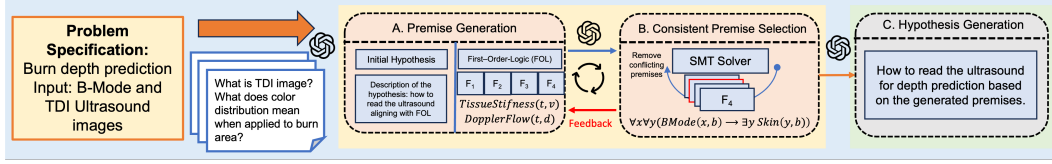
Automated hypothesis generation pipeline. Given the problem specification (burn depth prediction using B-Mode and TDI ultrasound), the system first constructs an input prompt by combining experimental descriptions with clinical context. (A) The language model generates initial hypotheses and corresponding first-order logic (FOL) premises describing how to interpret ultrasound patterns. (B) An SMT solver iteratively filters out conflicting premises and enforces logical consistency, providing feedback to refine the generated rules. (C) The validated premises are summarized into a final natural-language hypothesis that guides the vision-language model in subsequent burn depth assessment.
